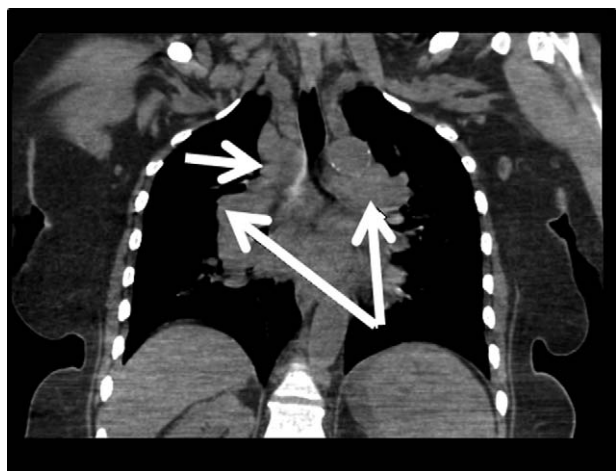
Computed tomography scan of the chest showing para tracheal (small arrow) and bilateral hilar lymph adenopathy (long arrows).
